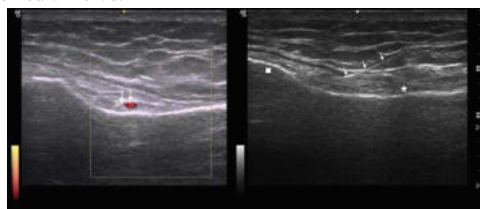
8 showing knee joint with Longitudinal ultrasound image of the knee at the level of the tibial medial epicondyle.⁸
